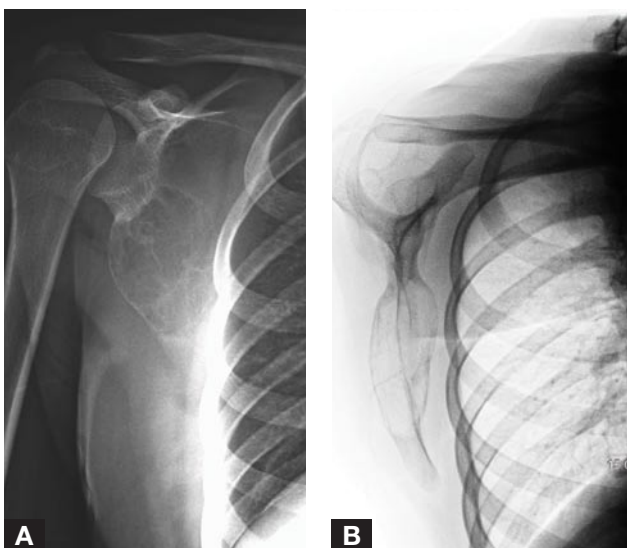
Plain anteroposterior (A) and scapular (B) radiographs show expansile lesion of scapula.
